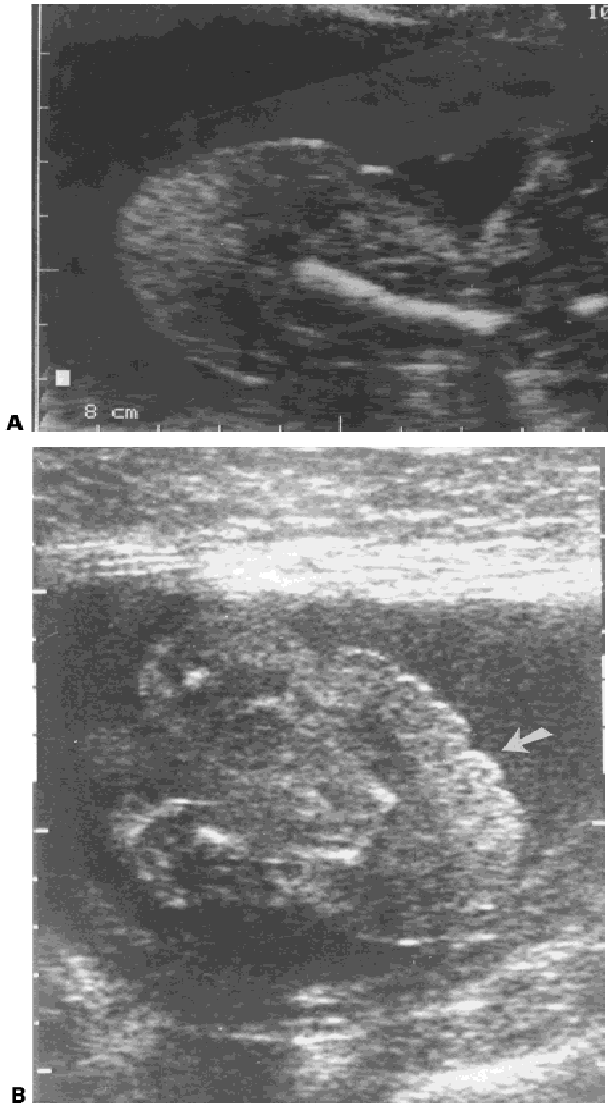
Intrauterine sonographic appearance of congenital fibrosarcoma. (A) Sonogram shows a soft tissue growth involving the left thigh. (B) Another scan of the left thigh shows swelling with redundant overlying skin (arrow).
